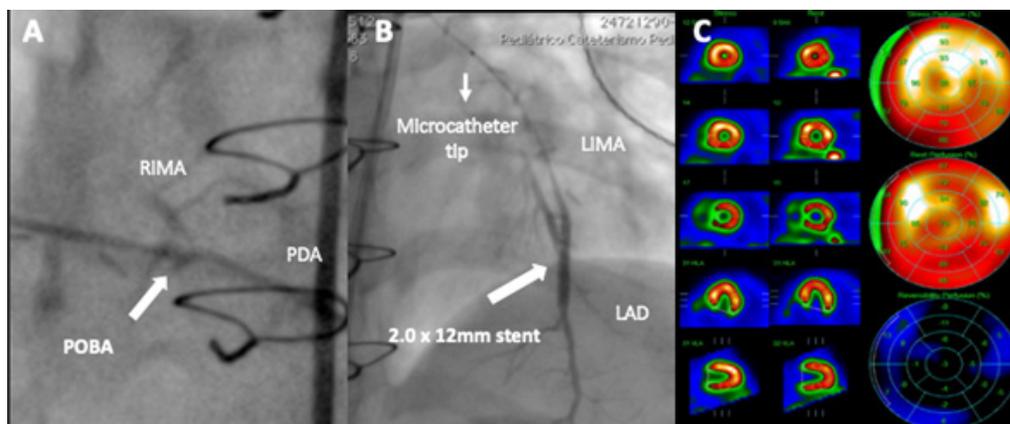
Post-procedural results. A) POBA to RIMA-PDA; B) Stenting to LIMA-LAD; C) Follow-up SPECT with mild perfusion defect.
